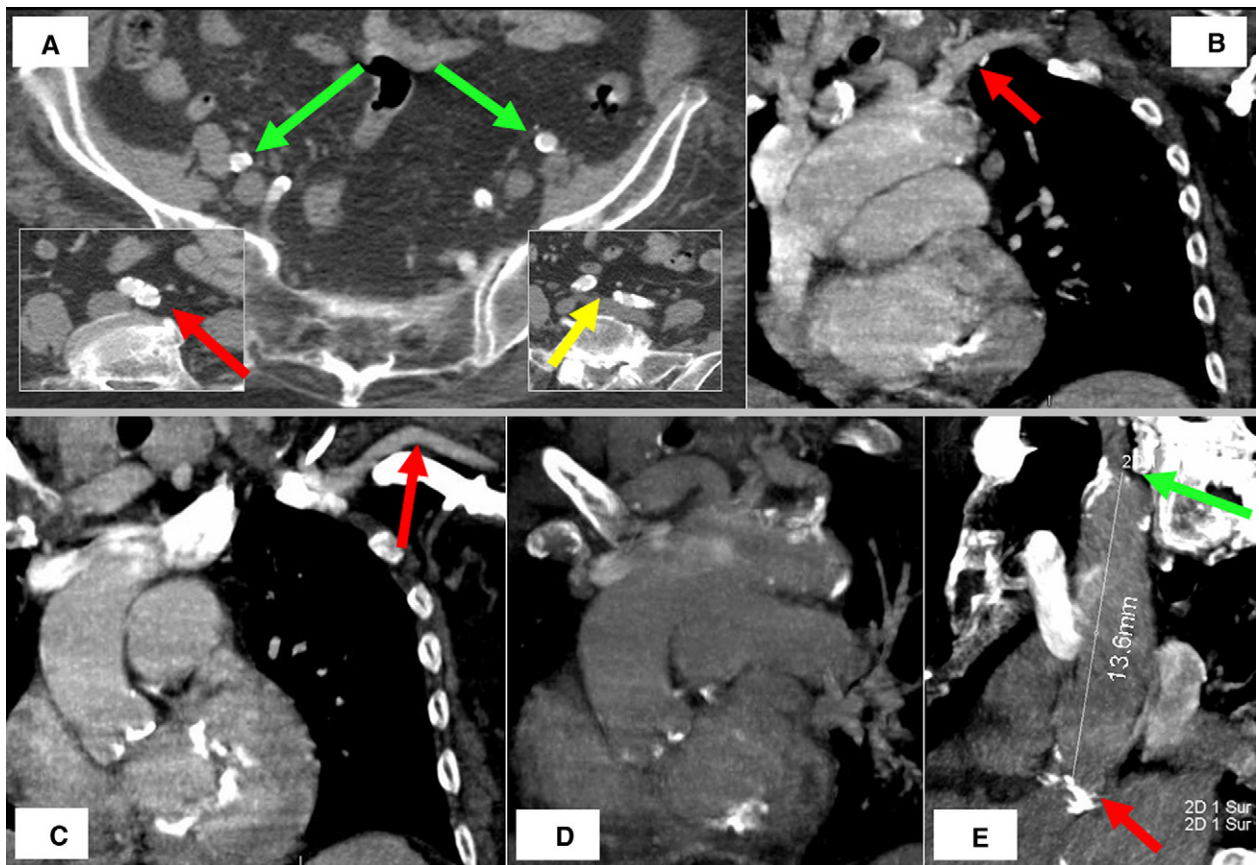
A, Multislice computed tomography showing calcified iliofemoral vessels (*red arrow*, ostia of the primary iliac arteries; *yellow arrow*, primary iliac arteries; *green arrows*, external iliac arteries). B, Multislice computed tomographic reconstruction showing left axillary artery (*red arrow*). C, Multislice computed tomographic reconstruction showing left axillary artery (*red arrow*). D, Multislice computed tomography demonstrating the aortic annulus, the ascending aorta, the aortic arch, and the ostium of the left subclavian artery. E, Multislice computed tomographic reconstruction demonstrating the distance between the aortic annulus (*red arrow*) and the ostium of the left subclavian artery (*green arrow*).
